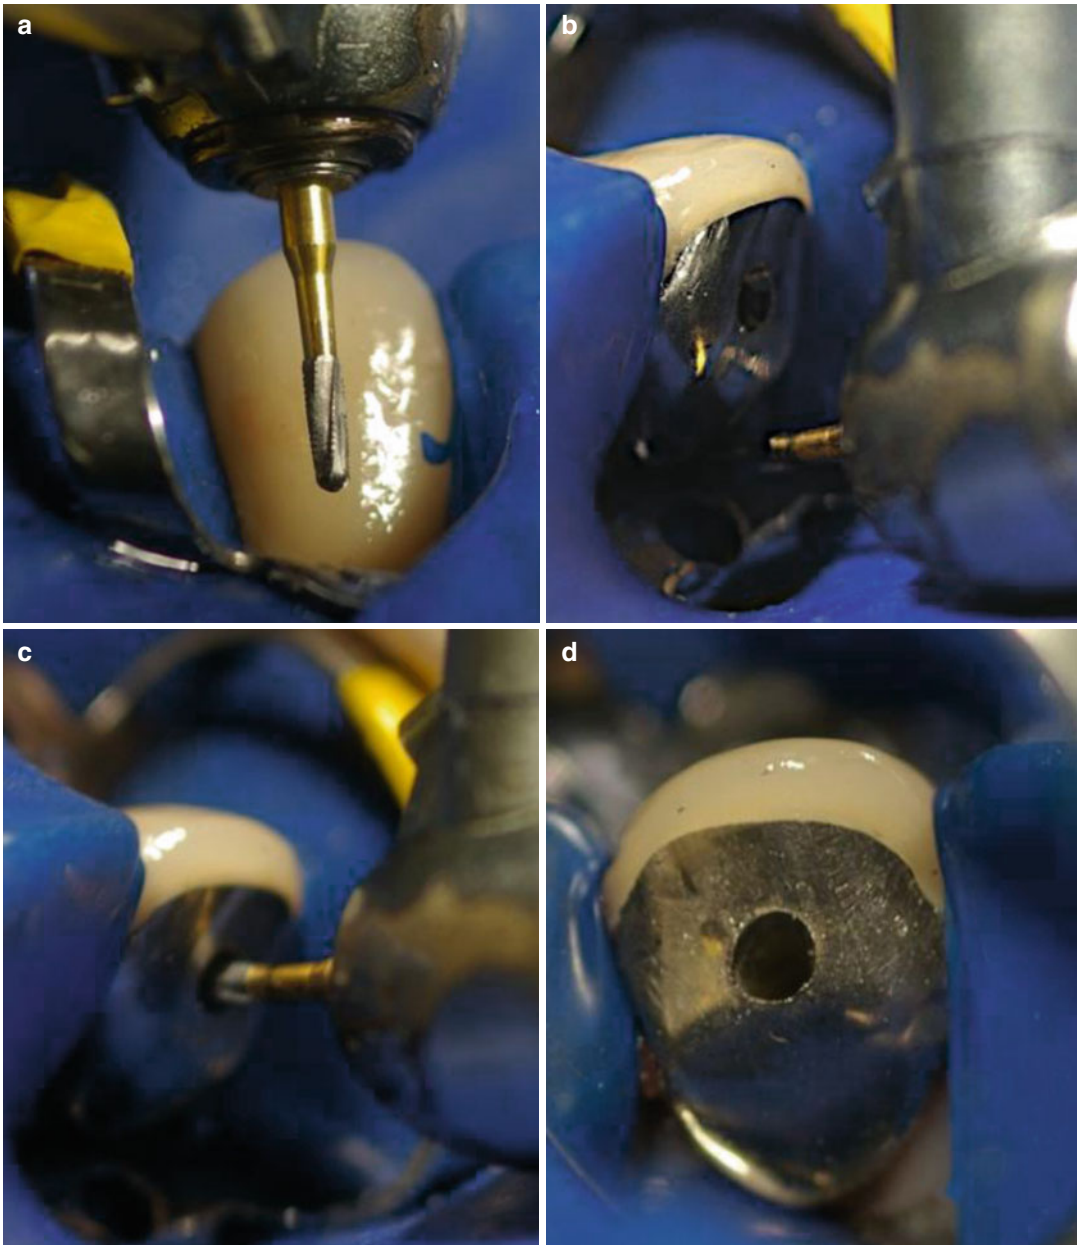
Clinical photographs showing access preparation through a porcelain-metal crown. (a) Tungsten carbide bur is selected and (b) carefully aligned to long axis of the tooth to (c, d) gain initial access through the metal infrastructure. Preoperative radiographs and clinical
